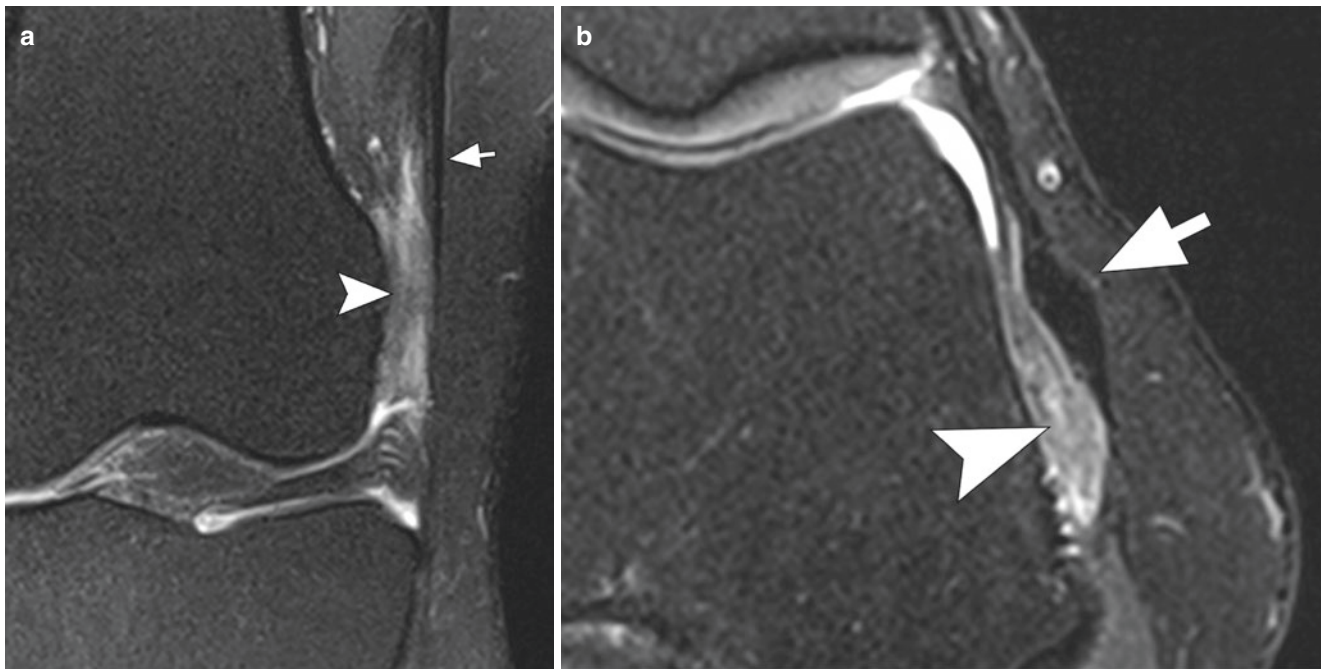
Iliotibial band friction syndrome. (a) Coronal and (b) axial T2-weighted images with fat suppression demonstrate edema in the fat pad (arrowheads) between the lateral femoral condyle and the iliotibial band (arrows)
